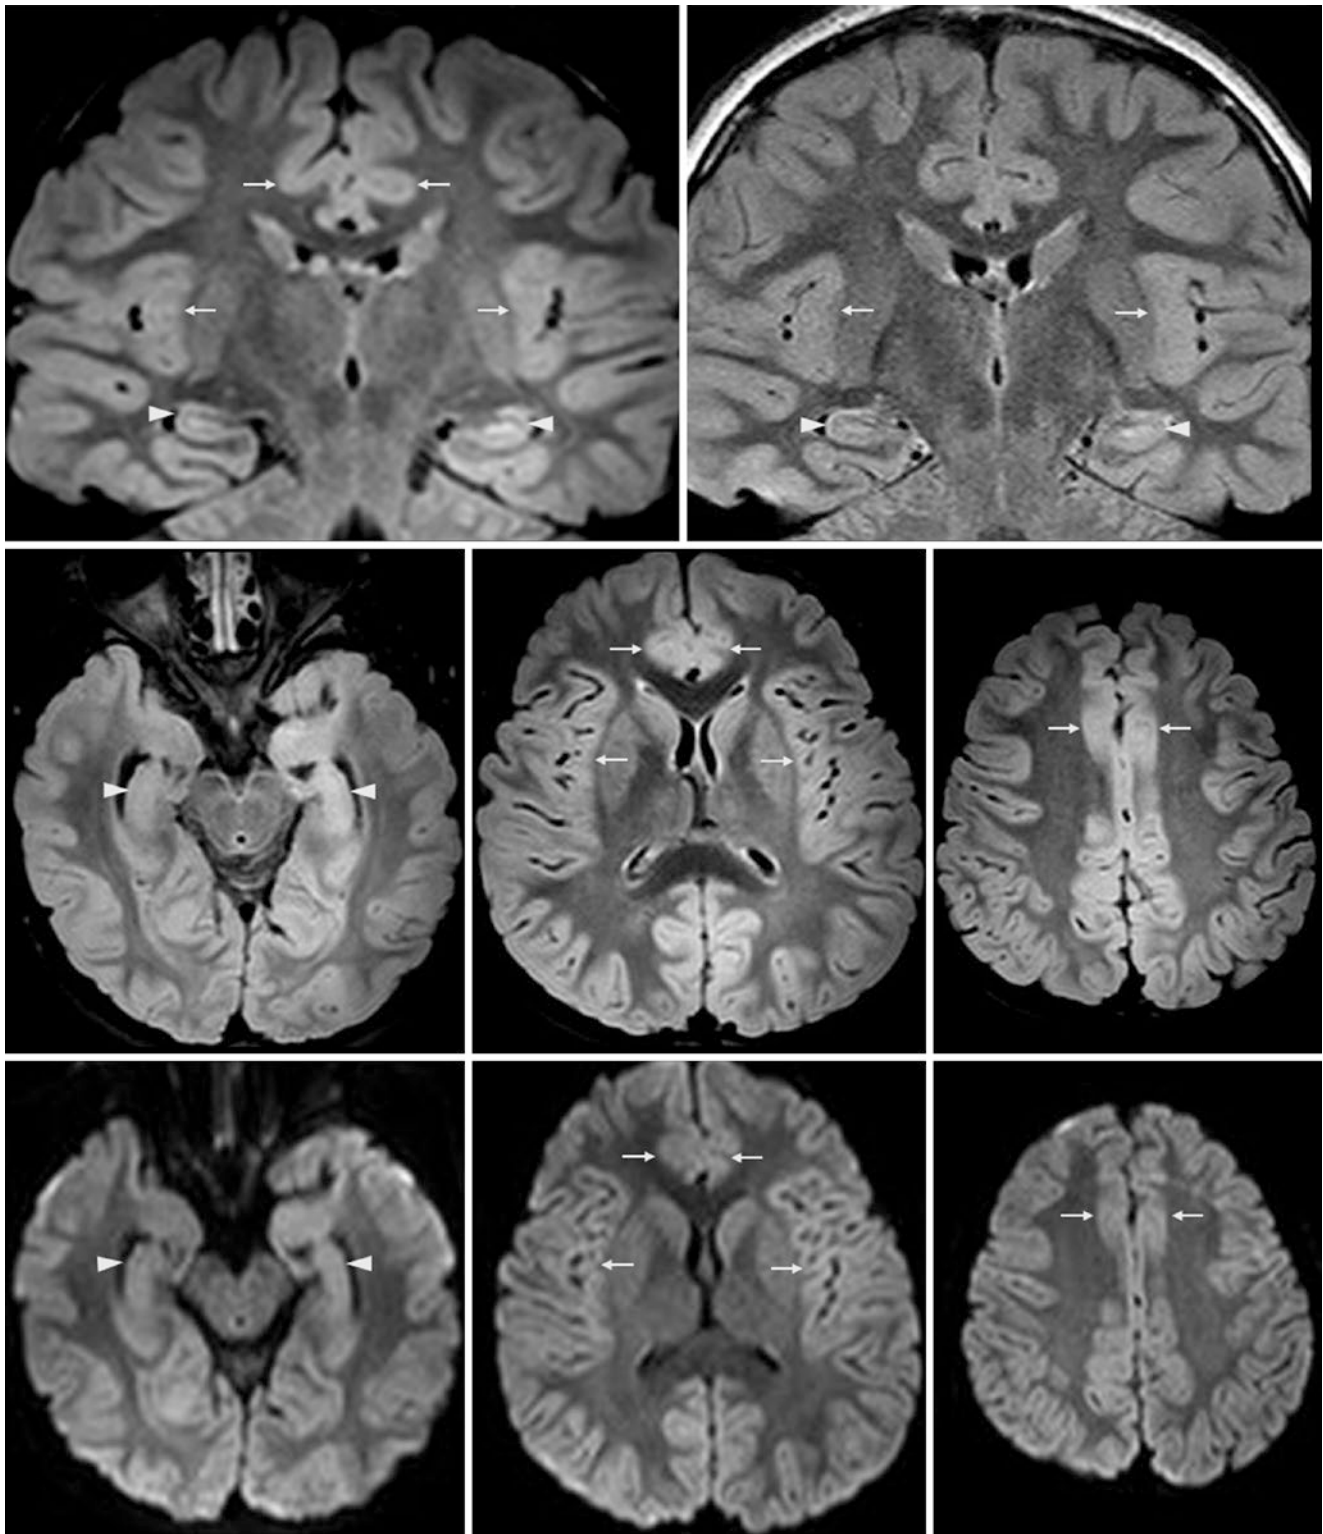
Comparison between 3D and 2D FLAIR in causing cortical pseudolesions in images from a 6-year-old with an otherwise negative 3 T MR for altered mentation. *Top row:* A 3D-reformatted coronal FLAIR image (*left*) shows bilaterally hyperintense hippocampi (*arrowheads*), and insulae and cingulate gyri (*thin arrows* for both). The artifacts are more prominent centrally and are not nearly as hyperintense on
